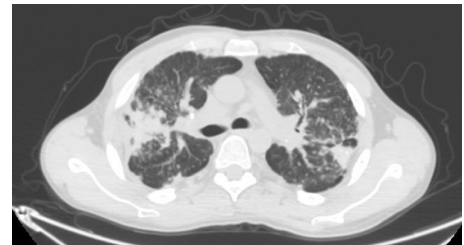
HRCT of Case 5 demonstrates severe fibrotic changes in the upper lobes.
